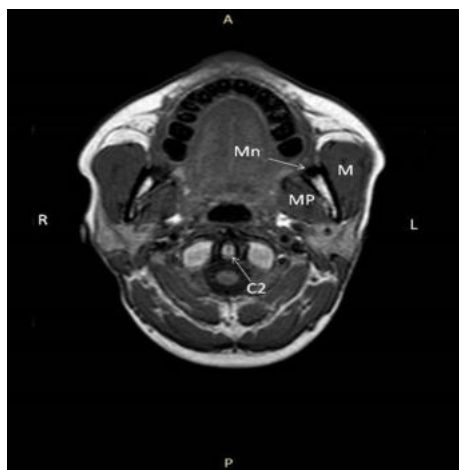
MRI SCAN OF HEAD REGION (T1 – AXIAL IMAGE)
